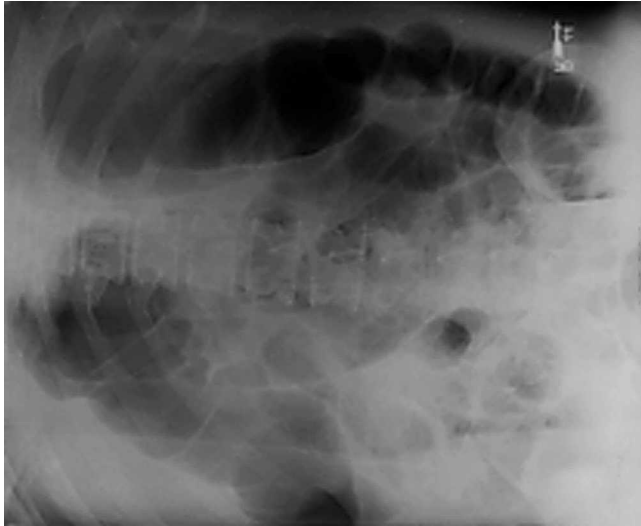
Abdominal X-ray. Persistent dilated loops of bowel seen after colonoscopy.
